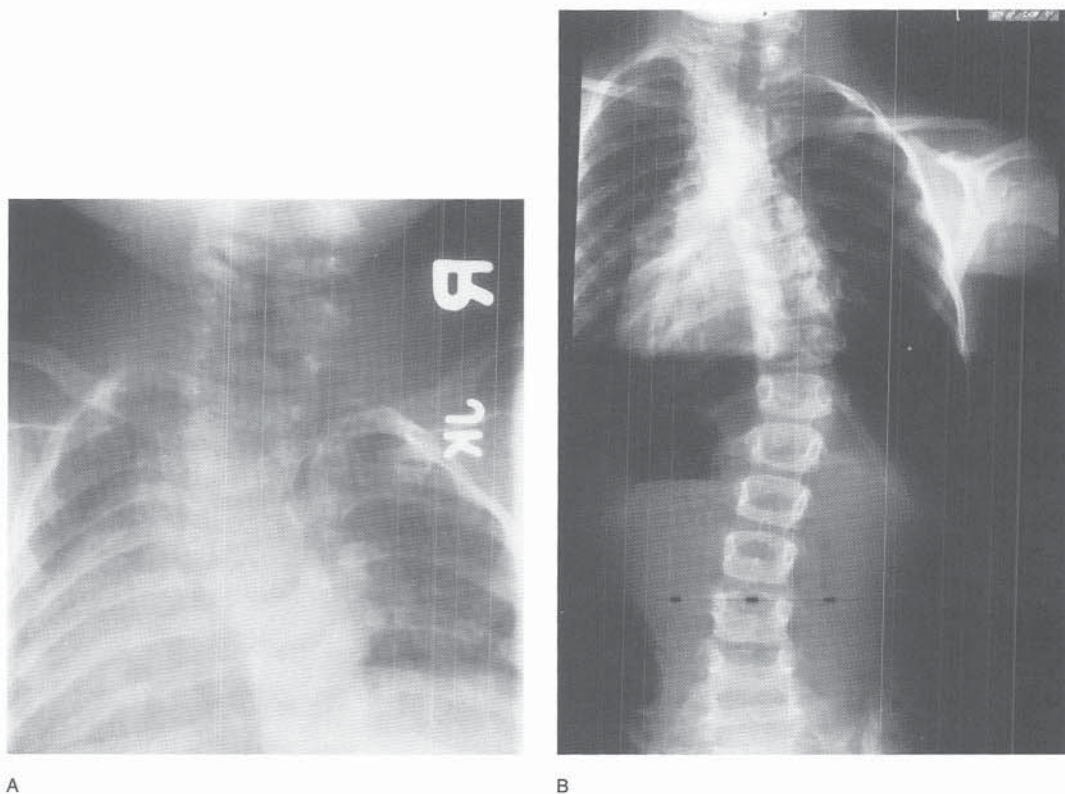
Radiographic appearance of a girl with numerous congenital abnormalities in the upper thoracic spine, including hemivertebrae on the convexity and fused ribs on the concavity. These abnormalities are well demonstrated on a radiograph obtained at age 7 months (A). Because of the high risk of progression, anterior and posterior in situ fusion between T2 and T8 was performed at age 16 months. A compensatory curve developed below which measured 40 degrees at age 7 years (B). This compensatory curve was subsequently managed with a brace.
